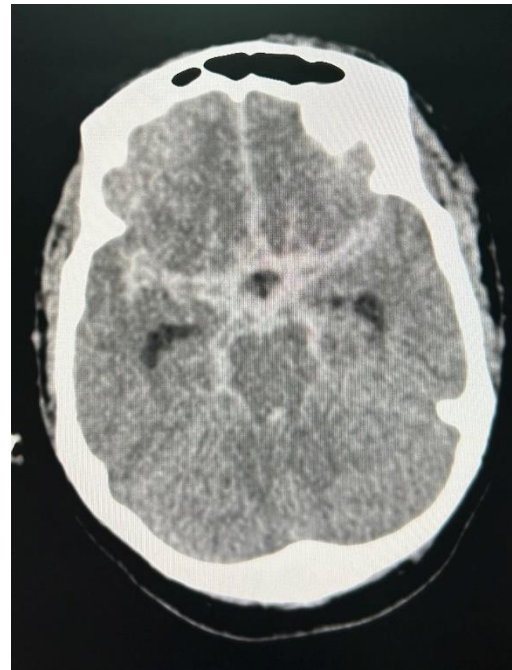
Non contrast CT head axial view showing diffuse and thick basal subarachnoid hemorrhage with evoking hydrocephalus, diffuse cerebral edema
